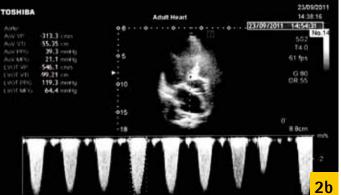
Echocardiography at hospitalization 2a: 4-chamber view 2b: Doppler echocardio-graphy at the level of left ventricular outflow tract
